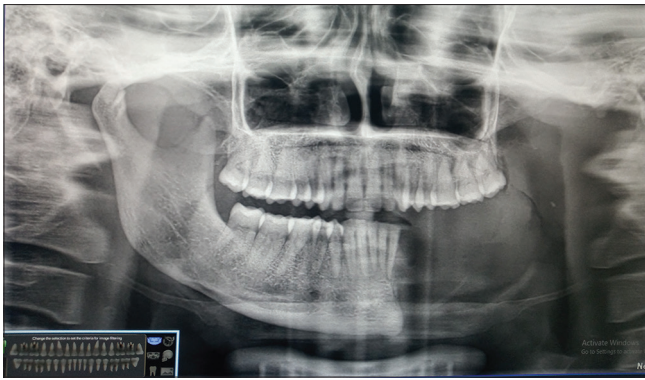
Follow-up OPG (6-month post-operative). OPG: Orthopantomogram
